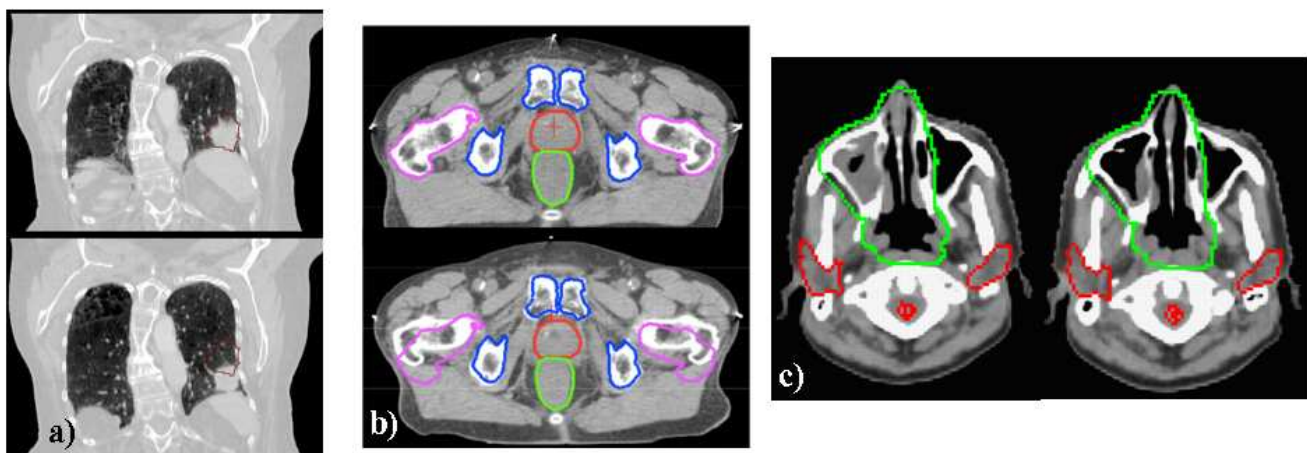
Different types of organ motion. In a) a lung tumor is shown in two extreme motion states. This is an example for intrafractional motion. In b) two CT scans of a prostate patient are compared. Interfractional position changes are visible. In c) density variations between two CT scans are shown. Figure from (Engelsman and Bert, 2011).
